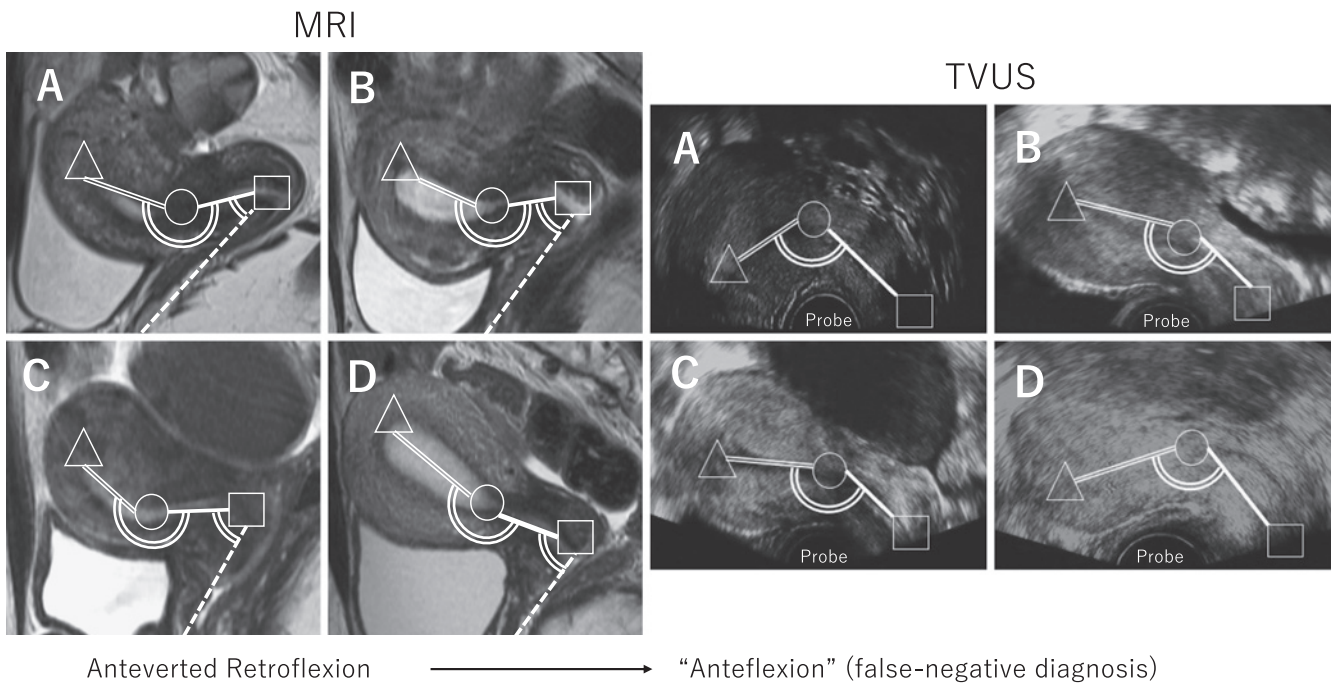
Median sagittal sections of four representative false-negative cases out of 28 cases of anteverted uterine retroflexion obtained using magnetic resonance imaging (MRI) and transvaginal ultrasound (TVUS).
